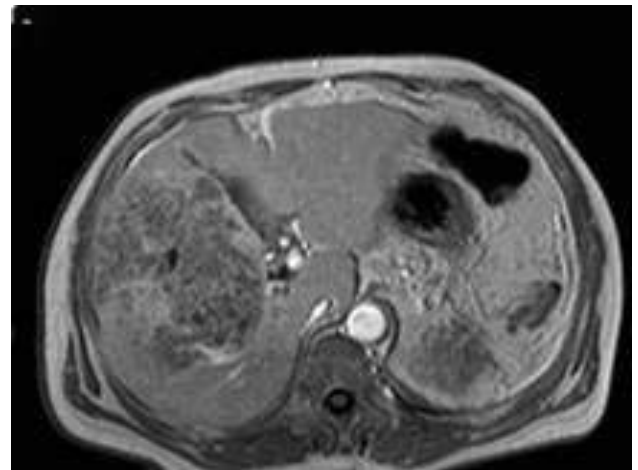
MR images in 68-year-old man with large HCC of the right lobe. The lesion presents low T1 (a), high T2 signal (b), remains hyperintense on DW MRI at $b = 1000 \text{ sec/mm}^2$ (c), low ADC 0.96 s/mm^2 (d), compatible with a malignant lesion. Postcontrast T1-weighted image (e), confirms arterial-phase vascular non homogenous enhancing lesion.
